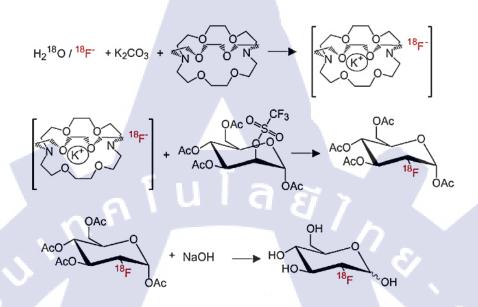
Radiosynthesis of [¹⁸F]-FDG.
